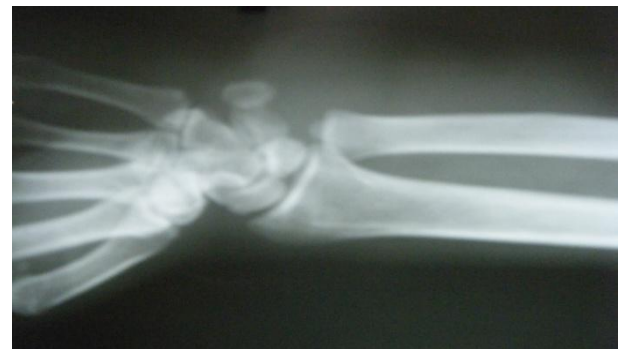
Radiograph of the right wrist joint showing no bony involvement.
